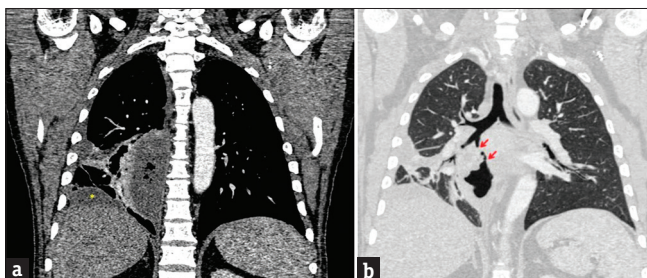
(a) Coronal contrast-enhanced computed tomography section of the chest showing an encysted pleural collection with right-sided pleural effusion (asterisk). (b) Coronal contrast-enhanced computed tomography section of the chest in the lung window showing the posterior basal subsegmental bronchus leading into the collection (arrows)
